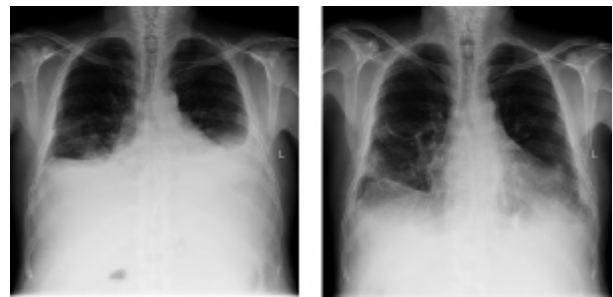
Chest X-rays before and after intrapleural instillation of rituximab.
